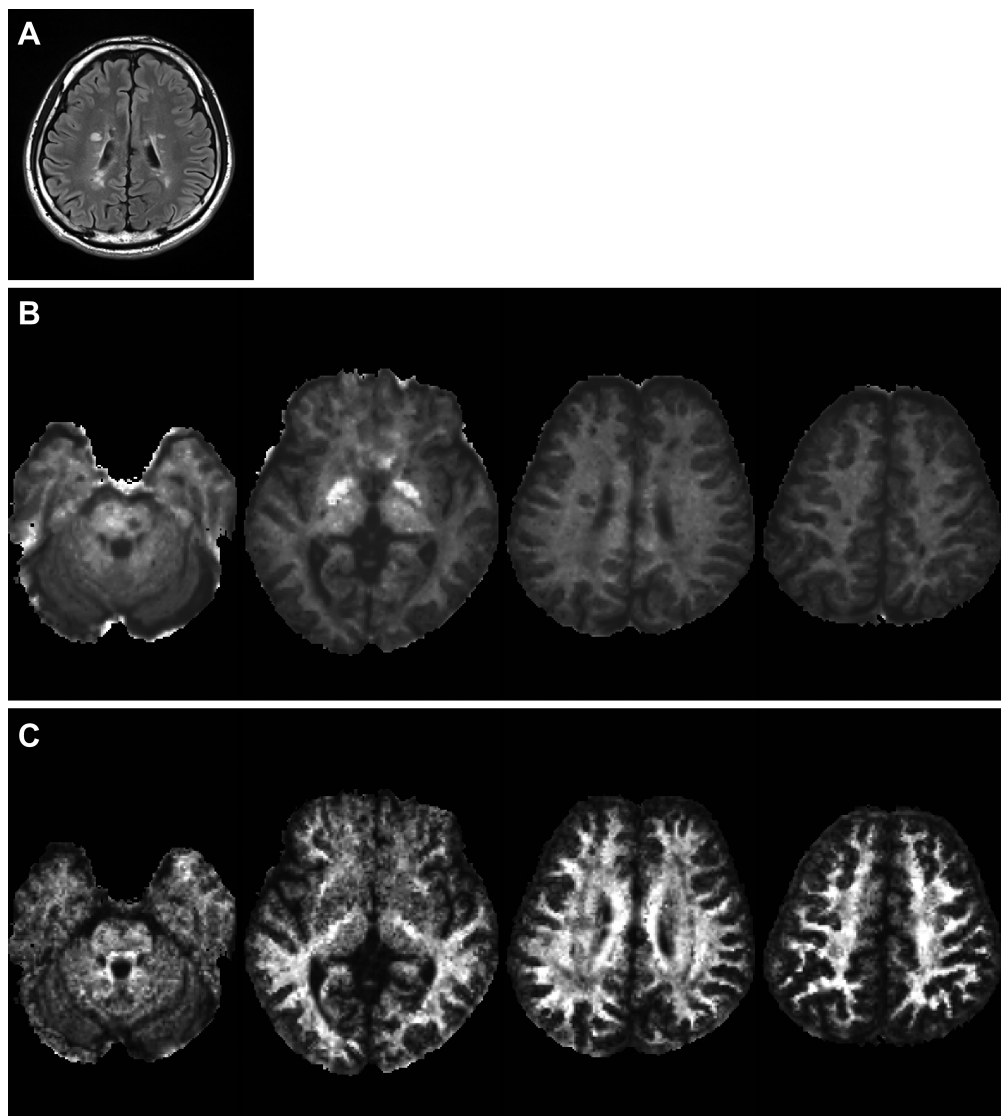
FLAIR image (a) shows hyperintense lesions in deep white matter, indicating MS plaques. Mean kurtosis maps (b) and FA maps (c) show the plaques as hypointense lesions. Note that, in the mean kurtosis map, white matter can be assessed without the influence of crossing fibers. FA, fractional anisotropy; FLAIR, fluid-attenuated inversion recovery.
